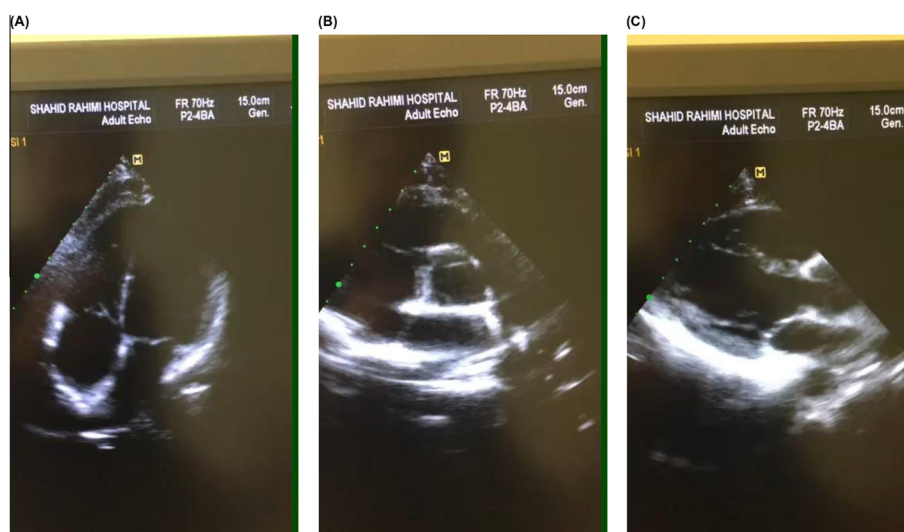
(A–C) Transthoracic echocardiography after 8 weeks' follow-up, showing mild pericardial effusion (0.6 cm) without respiratory variation and no evidence of constrictive pericarditis (septal bounce or hemodynamic effect).
